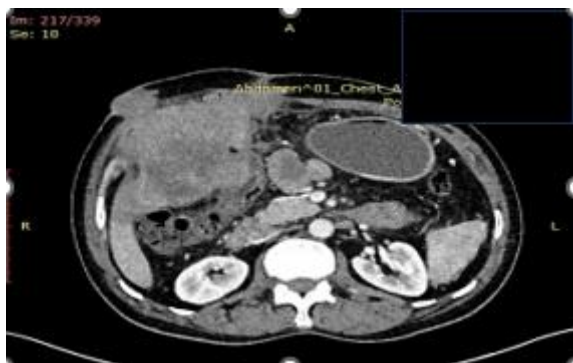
Axial contrast-enhanced CT image showing conglomerated heterogeneously enhancing metastatic lymph nodes in the peripancreatic and periportal regions
